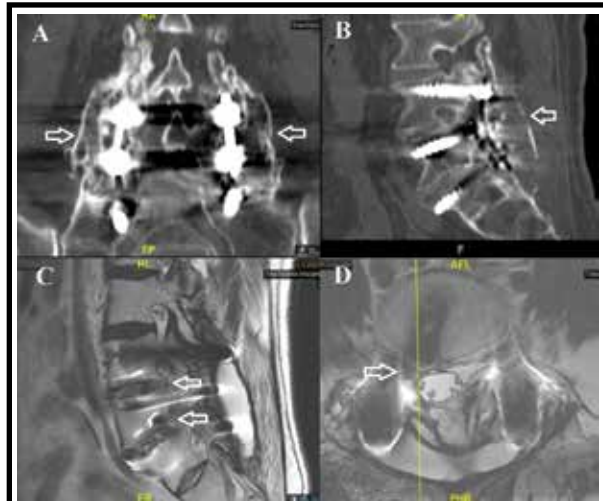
Preoperative lumbar CT and MRI were demonstrating right L3-4 and L4-5 foraminal narrowing post-TLIF and large posterolateral fusion. A. Coronal CT image demonstrates instrumented L3-5 fusion with large posterolateral fusion mass (open arrows). B. Sagittal CT reconstruction demonstrates instrumented L3-5 fusion with large posterolateral fusion mass (open arrow). C. Sagittal T2-weighted MR image demonstrating the right L3-4 and L4-5 foraminal compression (open arrows). D. Axial T2-weighted MR image demonstrating the right L4-5 foraminal narrowing (open arrow).
